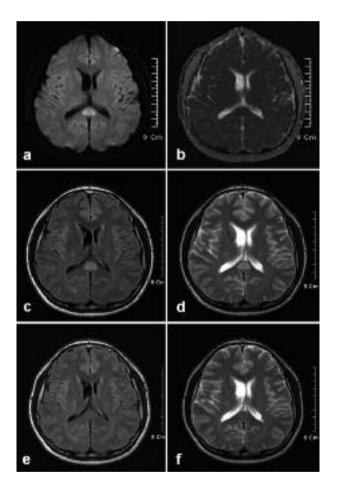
Initial axial diffusion-weighted MR image on day 3 of febrile illness showed oval-shaped high signal intensity (A) and restricted diffusion with reduced ADC values in the splenium of corpus callosum (B). The lesion showed hyperintensity on FLAIR and T2-weighted image at the same location (C, D). Follow-up brain MRI was performed one-month later from the initial admission. Previous splenial lesion was completely disappeared on FLAIR and T-2 weighted MR images (E, F).
